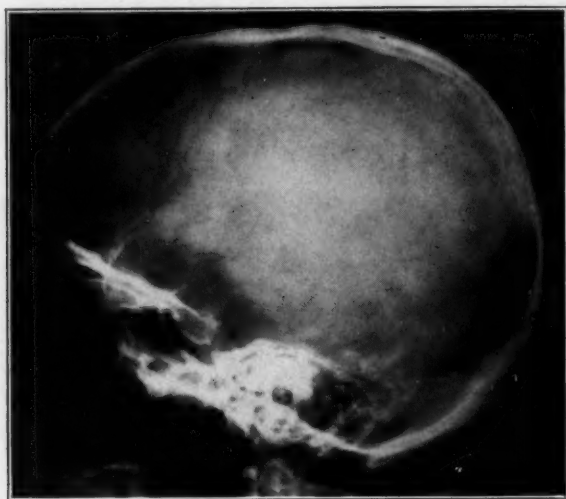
(case 2).—Roentgenogram of the skull, showing the small sella turcica and a slight atrophy of posterior clinoid processes.
